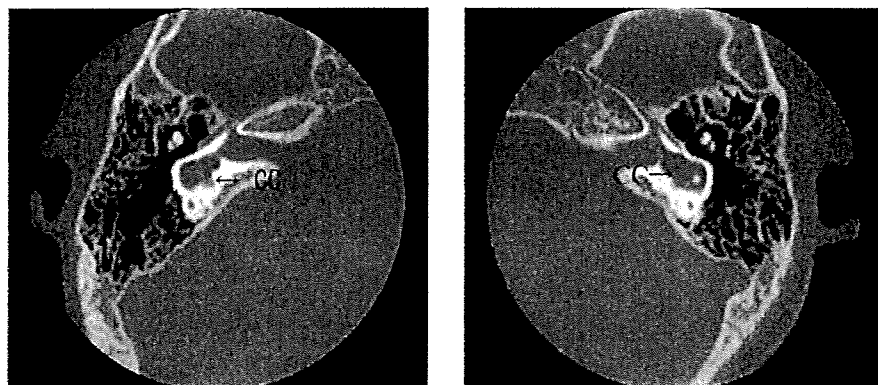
Patient 1: 7-year-old boy, CC deformity, left CI. CT scan demonstrated a deformity of the CC communicating with IAC. VEMPs were present in both ears before CI. VEMPs were present with the CI on.
